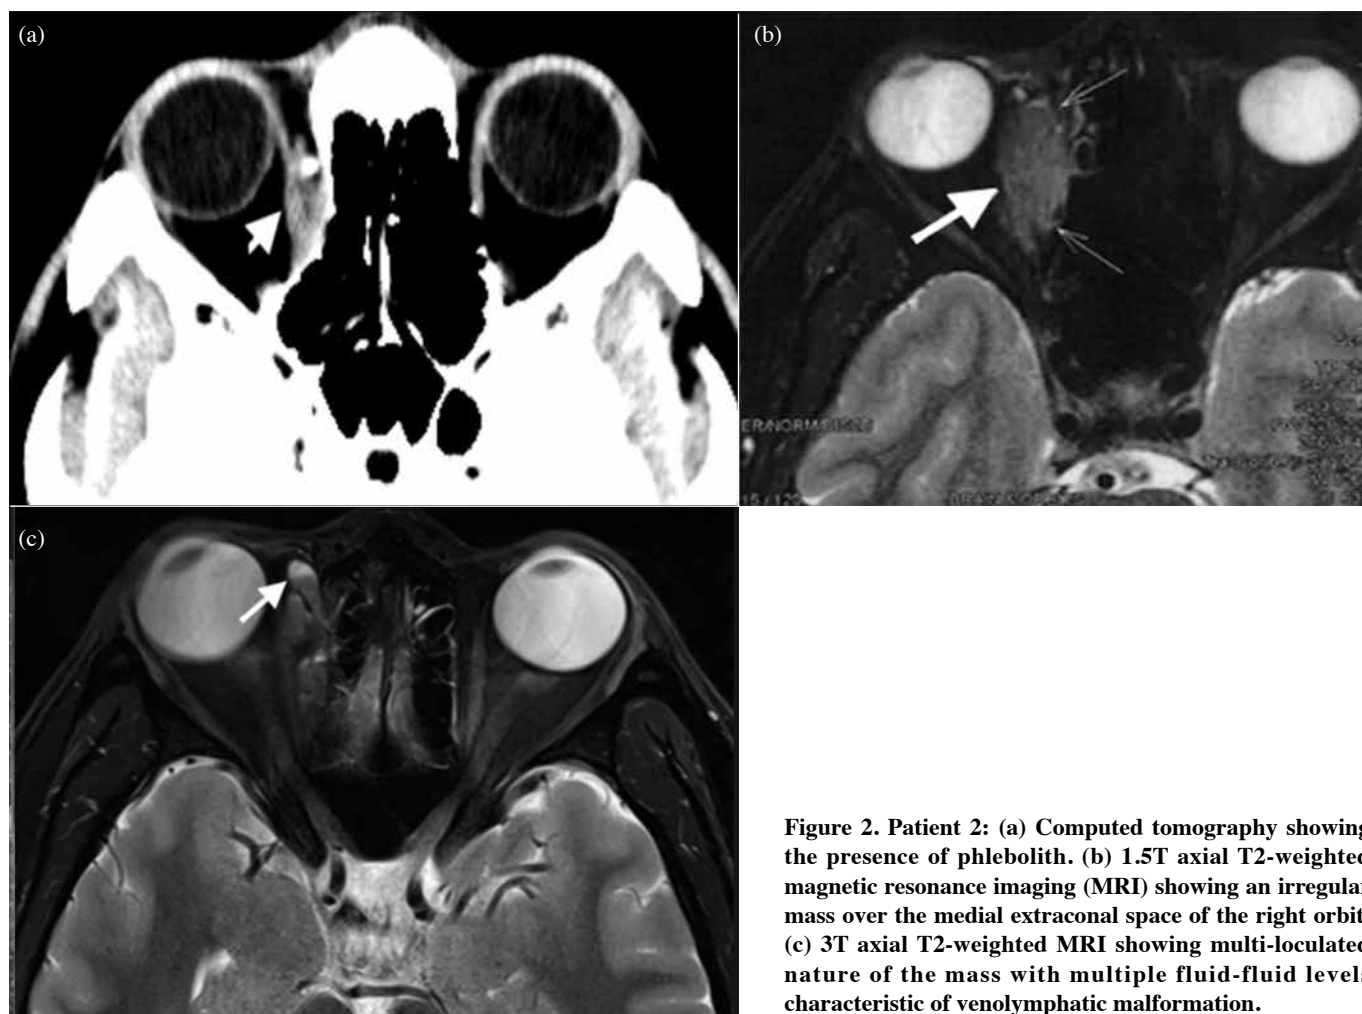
Patient 2: (a) Computed tomography showing the presence of phlebolith. (b) 1.5T axial T2-weighted magnetic resonance imaging (MRI) showing an irregular mass over the medial extraconal space of the right orbit. (c) 3T axial T2-weighted MRI showing multi-loculated nature of the mass with multiple fluid-fluid levels characteristic of venolymphatic malformation.
